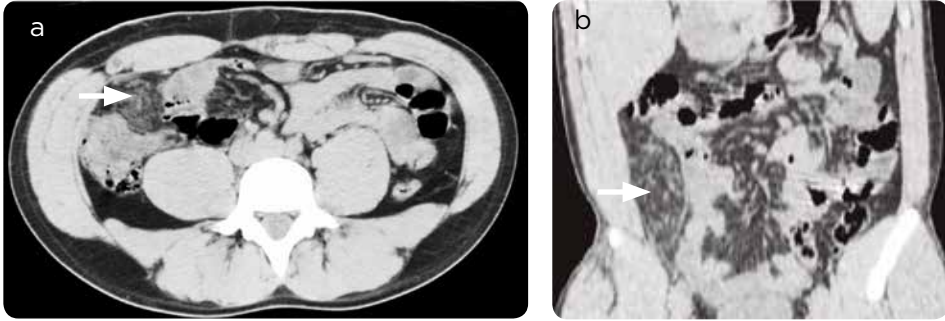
Simple multi-slice computed tomography of the abdomen (UROTAC). a) Axial section: increase in fat density in the topography of the greater omentum in the right iliac fossa (arrow) without free fluid or pneumoperitoneum. The cecal appendix is not properly identified. There is no hydronephrosis, nor ureteral stones that explain the cause of the pain. b) Multiplanar reconstruction, coronal cut. The location of the finding observed in the axial section is confirmed (arrow).
